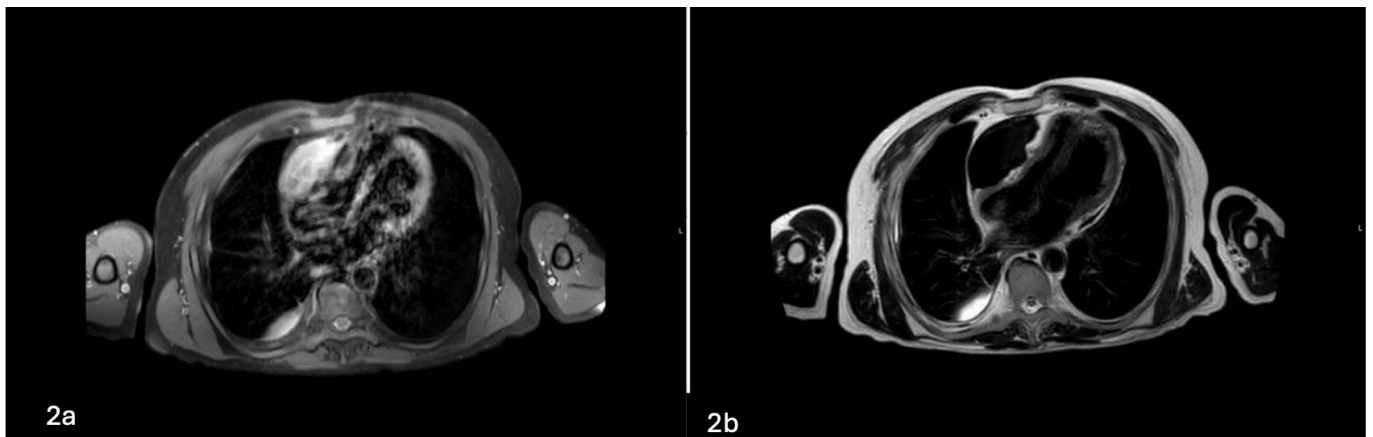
MRI T1 sequence examination
